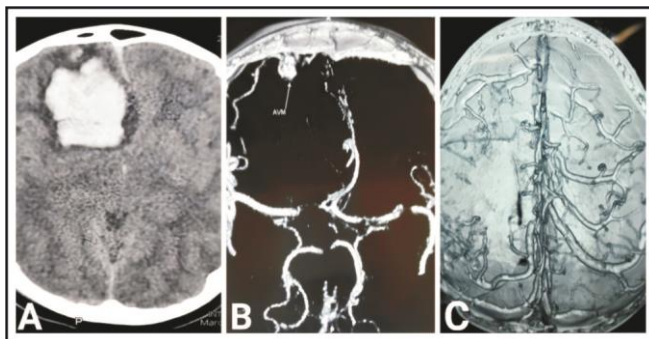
These Images are published after taking consent from the patient. CT; A: scan of brain plain axial view showing a right frontal lobe hemorrhage secondary to a ruptured AVM, B: Preoperative CT angiogram showing AVM nidus in right frontal lobe region, C: Postoperative CT angiogram of the same patient showing absence of AVM nidus.
